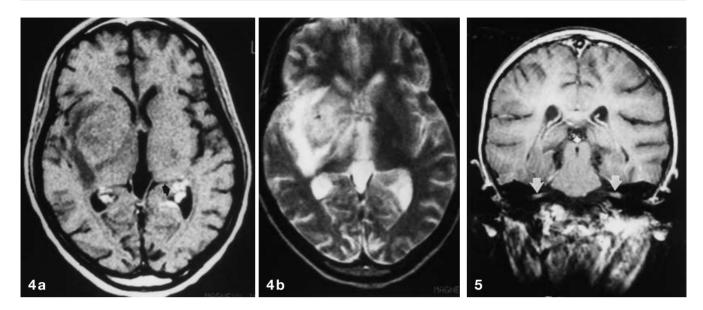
Axial T1-weighted contrast enhanced images (a) and axial T2-weighted images (b) in an HIV-positive patient with multifocal lymphoma. The enhancing periventricular component (*arrow*) and involvement of the basal ganglia are common for this disease
